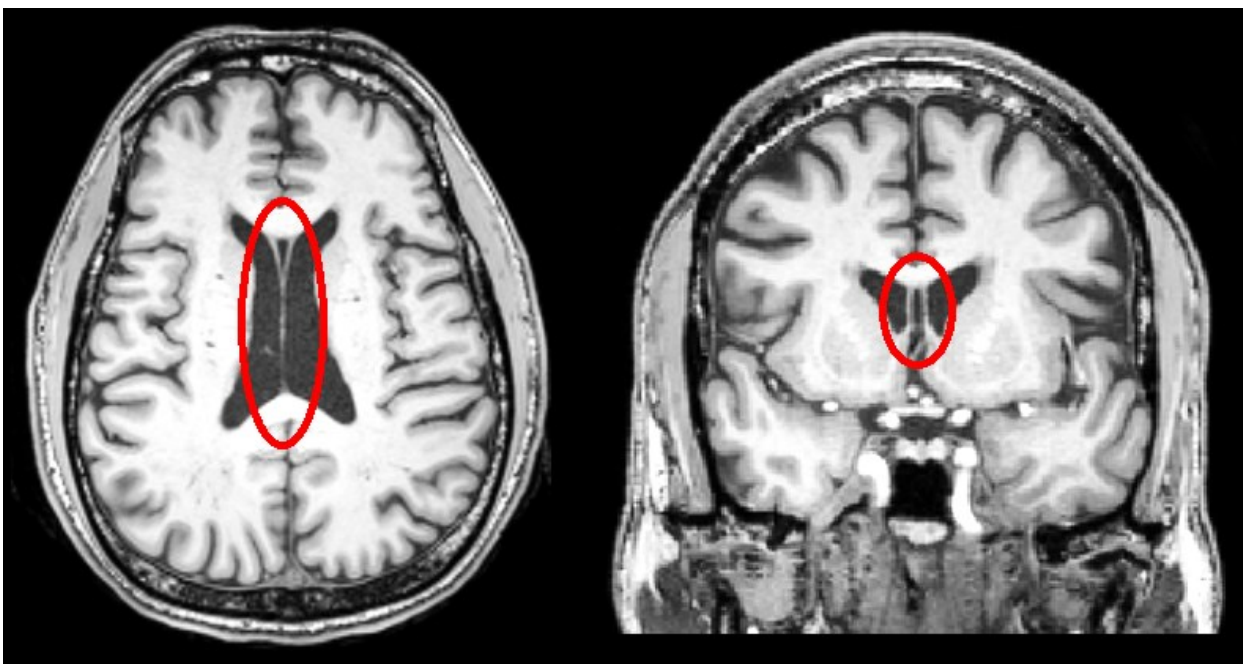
Septum pellucidum and CSP on structural MRI scans, adapted from Publication 1 [1]
